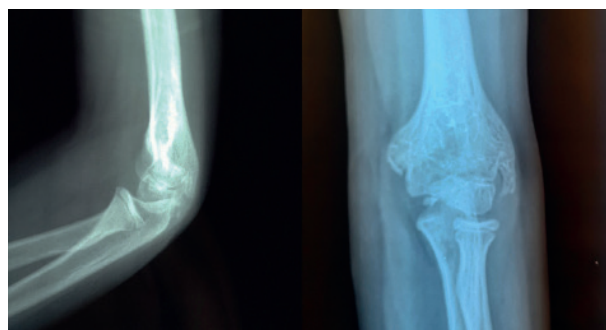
Lateral and Antero-posterior radiograph in postoperative
